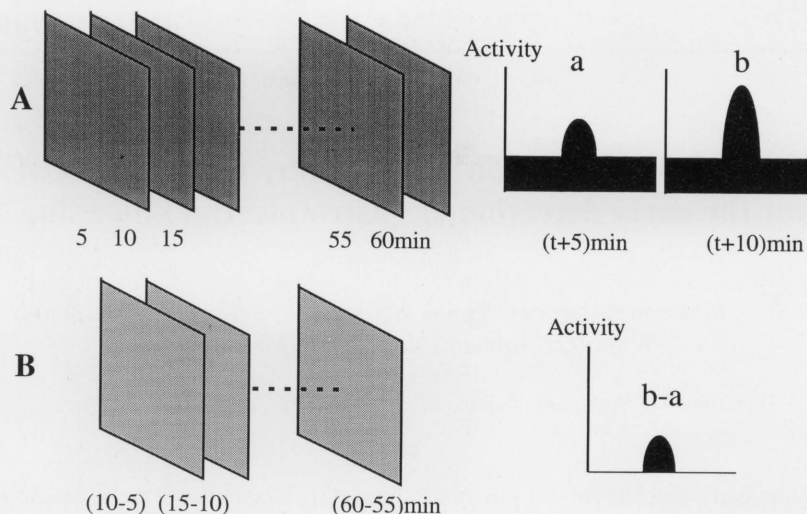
Principle of sequential subtraction scintigraphy and calculation of bleeding rate. A: Conventional scintigrams, B: Subtraction scintigrams.
